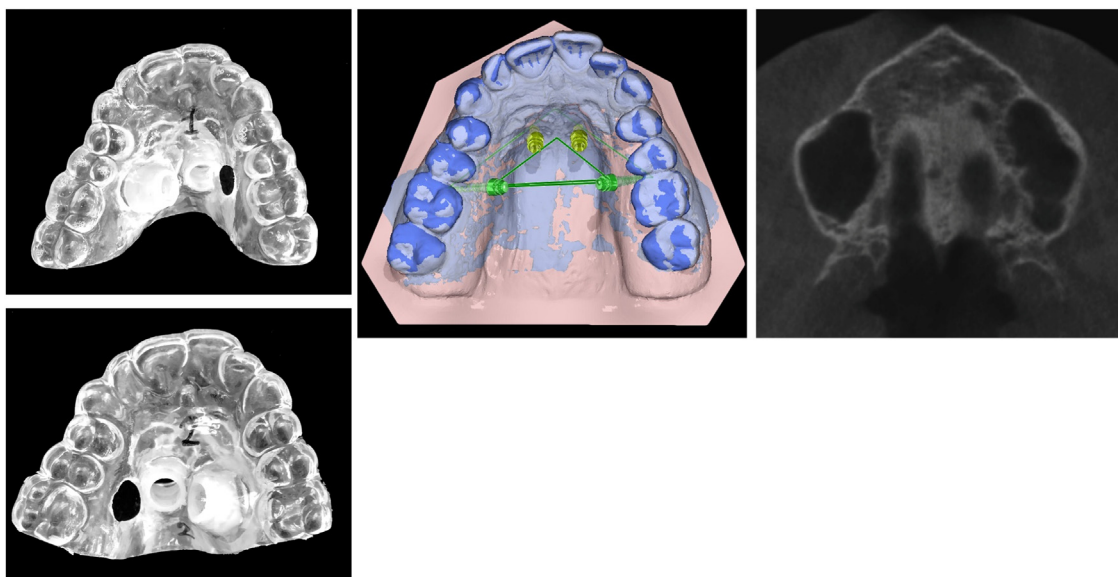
This case presents a 29-year-old female patient with a narrow maxilla. Prior to treatment, a CBCT examination was conducted to assess the patient's maturation stage (Stage D/E) and digital planning was performed to design surgical guides for the procedure.
